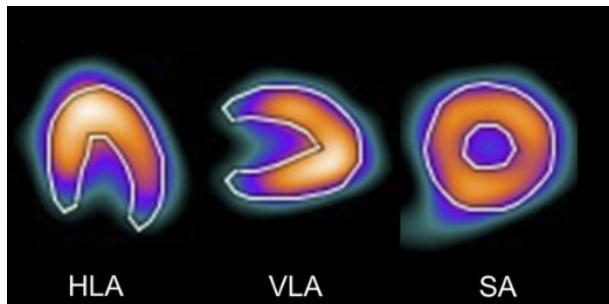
Normal cross-sectional images of the left ventricle retrieved using a D-SPECT (Yoneyama et al., 2017).
